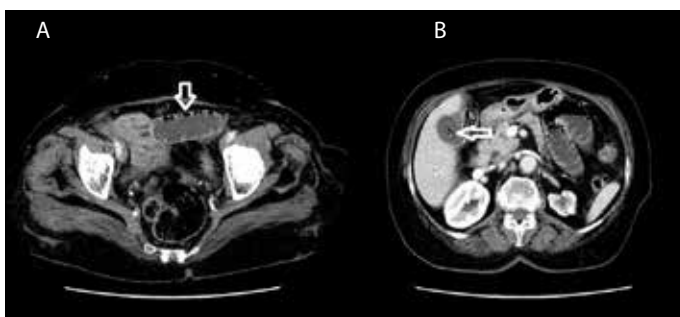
a, b. (a) Free air on the intestine wall in the CT scan. (b) Air and gall-stone in the gall bladder.
